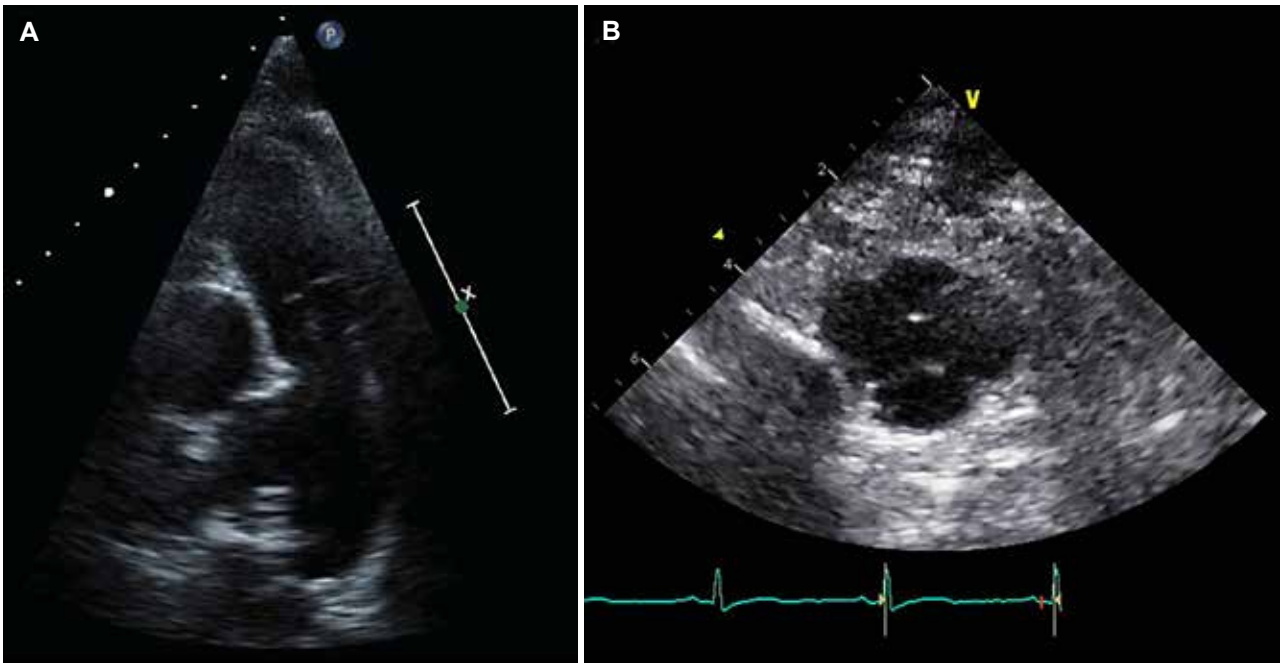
Two-dimensional echocardiography, showing a thickened pulmonary valve with systolic doming, a dilated main pulmonary artery (A) and a quadricuspid pulmonary valve in the diastolic frame (B).
